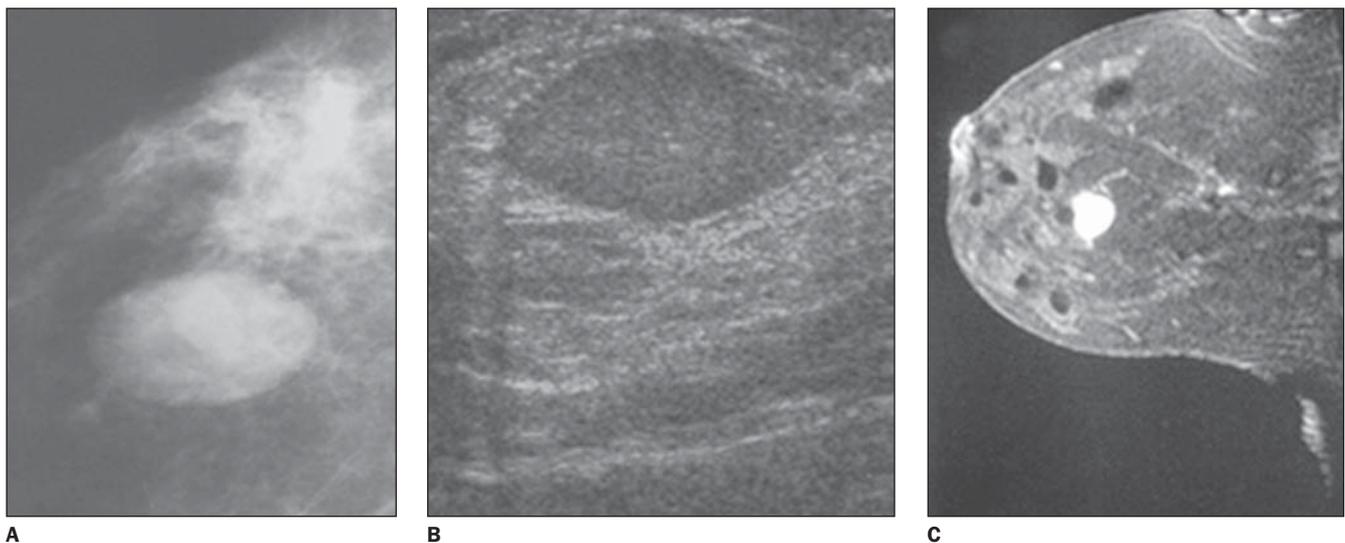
Examples of nodules classified as BI-RADS category 3. A: Mammographic image of an isodense, well-circumscribed ovoid nodule. B: Sonographic image of hypoechoic, well-circumscribed ovoid nodule, presenting parallel orientation and without posterior acoustic shadowing. C: Magnetic resonance image showing homogeneously contrast-enhanced round, well-circumscribed nodule.
